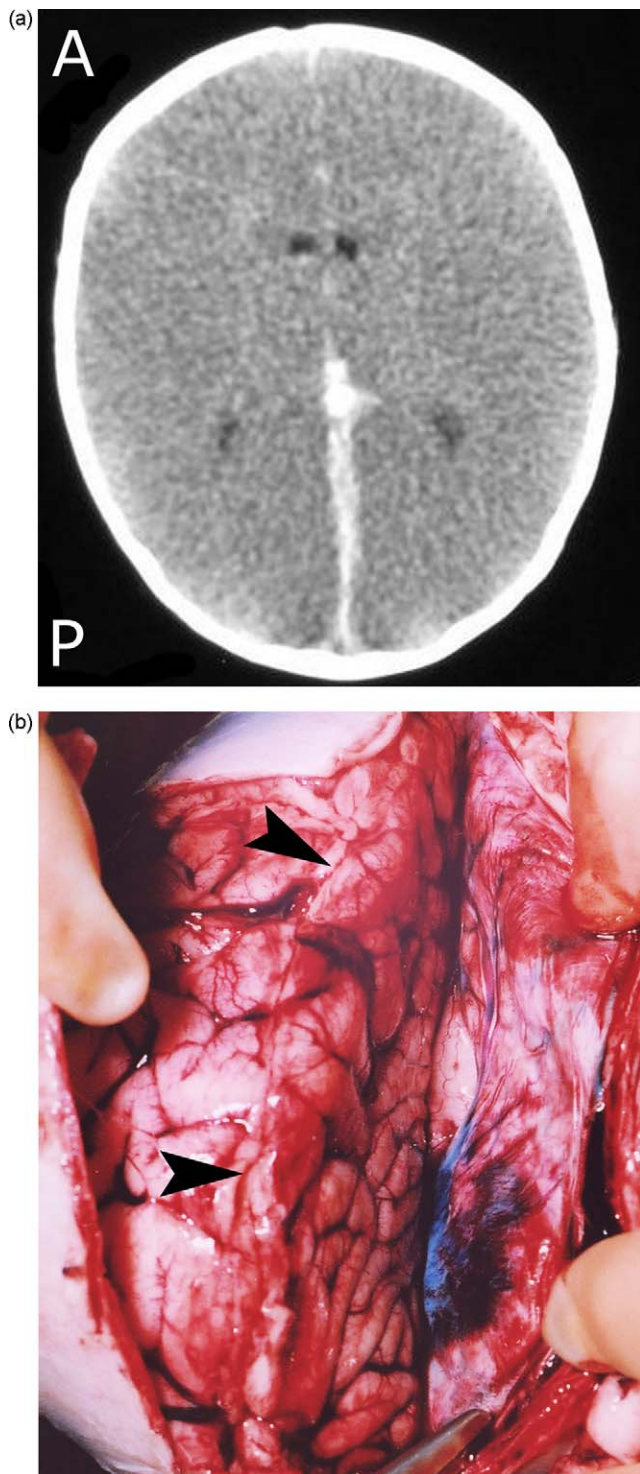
4-Month-old infant, sudden unexpected death. (a) CT scan of brain showing midline linear high signal in the position of the falx. (b) Autopsy picture of the same case. The falx is seen in the midline. Arrows indicate the upper parafalcine border of the left cerebral hemisphere. There is a well-defined area of bleeding within the posterior falx but no SDH was seen in relation to any part of the falx or over the hemispheres.
